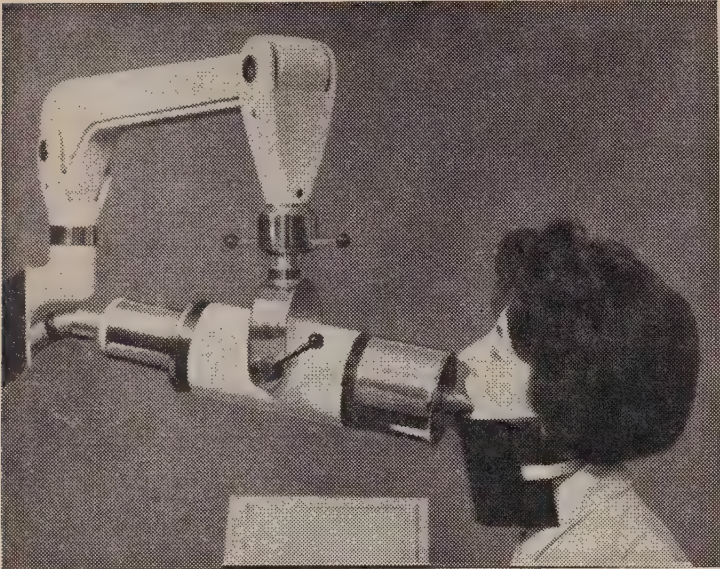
Panoramix. (Blackman, Sydney and Poyton, H.G. A manual of dental and oral radiography. Bristol, Wright, 1963.)
